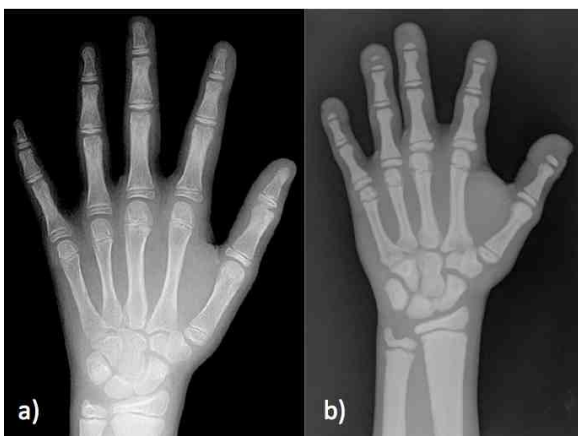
a) Left hand radiographs of a standard 10-year-old girl. b) The sister's left hand radiograph demonstrating reduced bone age, bony sclerosis and aplasia of distal phalanges.
